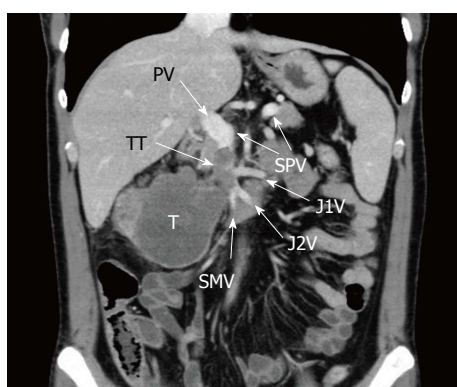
Preoperative computed tomography showing tumor thrombosis in the superior mesenteric vein in Case 5. T: Tumor; TT: Tumor thrombosis; PV: Portal vein; SPV: Splenic vein; SMV: Superior mesenteric vein; J1V: First jejunal vein; J2V: Second jejunal vein.
